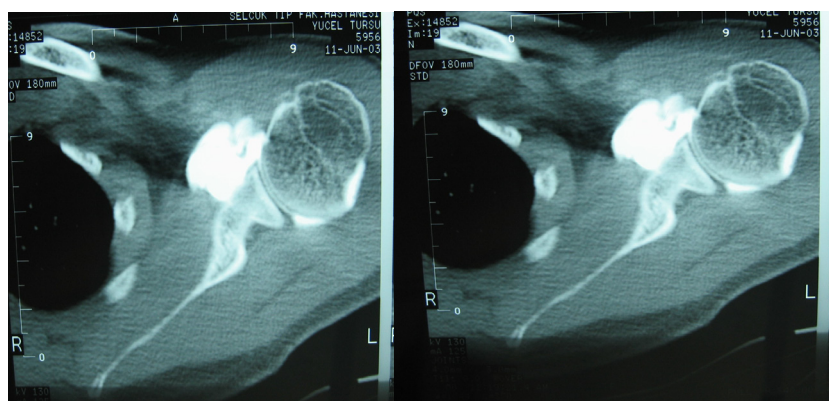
Arthro-CT and arthro-MRI view of Bankart lesion
